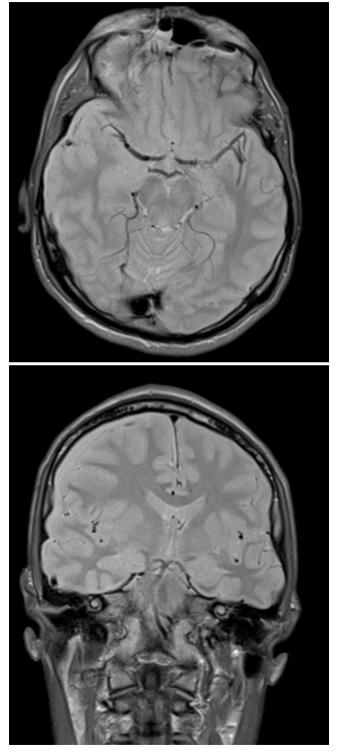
MRI of the head. Patient B.C. Age: 23. Patient's chart no. 32828/2013. Epidural empyema in the area of right frontal lobe, maximum thickness of approximately 5 mm. Minor mass-like effect observed as a shift of the ventricular system to the left and compression of the lumen of the right lateral ventricle.
